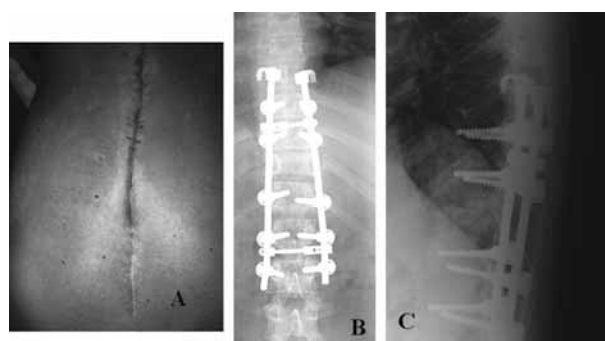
Case 2 : Clinical aspect and radiograph 6 months after application of VAC device.
